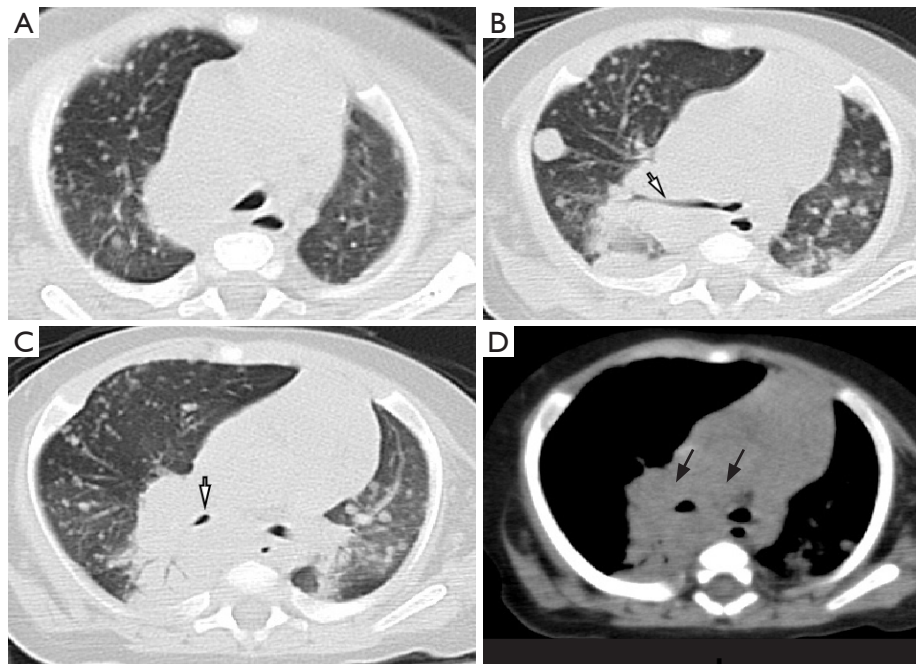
CT of a case of MDR (isoniazid, rifampicin, streptomycin) PTB (male, 5 months old). Widely distributed nodules of different sizes and multiple consolidation shadows in both lungs, uneven density, parts of the edges are unclear (A-C). (D) Mediastinum and multiple hilar lymphadenopathy (black arrows). Right main bronchus, right upper pulmonary bronchus, and middle bronchi are compressed and narrowed (white arrow). CT, computed tomography; MDR, multidrug-resistant; PTB, pulmonary tuberculosis.
